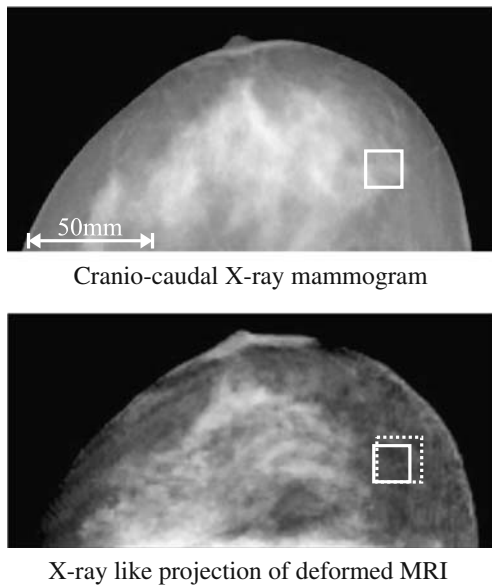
Dataset 2, estimated and original lesion position in the cranio-caudal X-ray mammogram. Top: Cranio-caudal X-ray mammogram. The real lesion position is given as a solid boundary box. Bottom: Projection of the MRI volume after matching. The boundary box of the projected MRI lesion is given as dotted line and the original position as a solid line. The center lesion distance is 4.3 mm and the area overlap amounts to 86%.
